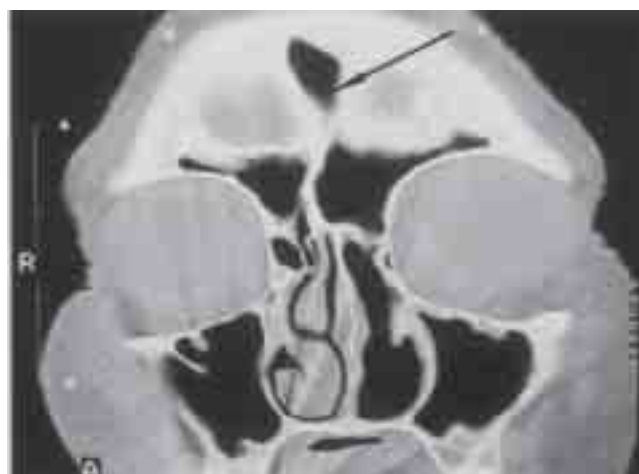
Patient C: Post-operative coronal CT scan view after removal of persisting concretion in the left frontal sinus (black arrow).
